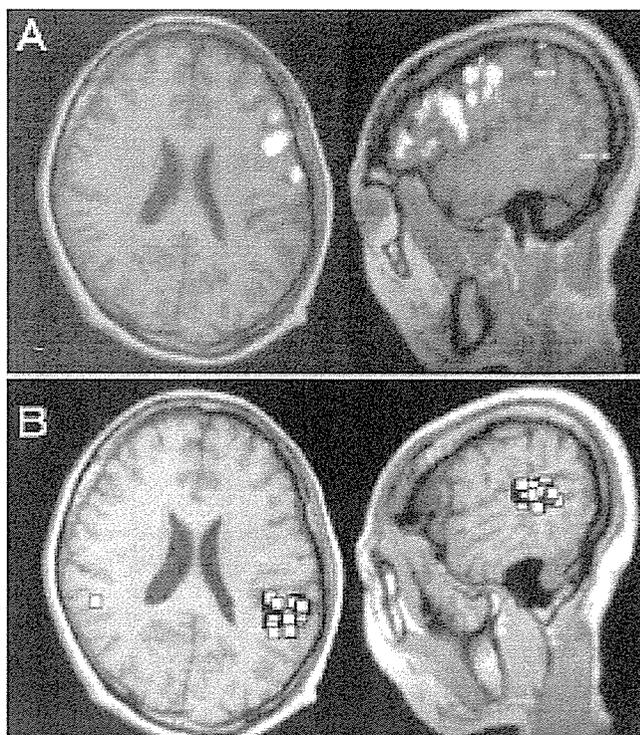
Case 22. A left frontal lobe lesion in a 44-year-old, right-handed woman. A: Functional MR images obtained during a language task, showing activations mainly in the left MFG and dorsolateral PFC. B: Magnetoencephalography source localizations obtained during a language task, superimposed on MR images, showing dipole clusters in the left superior temporal region, including the SMG. The left and right hemispheres contained 93 and 19 dipoles, respectively.
